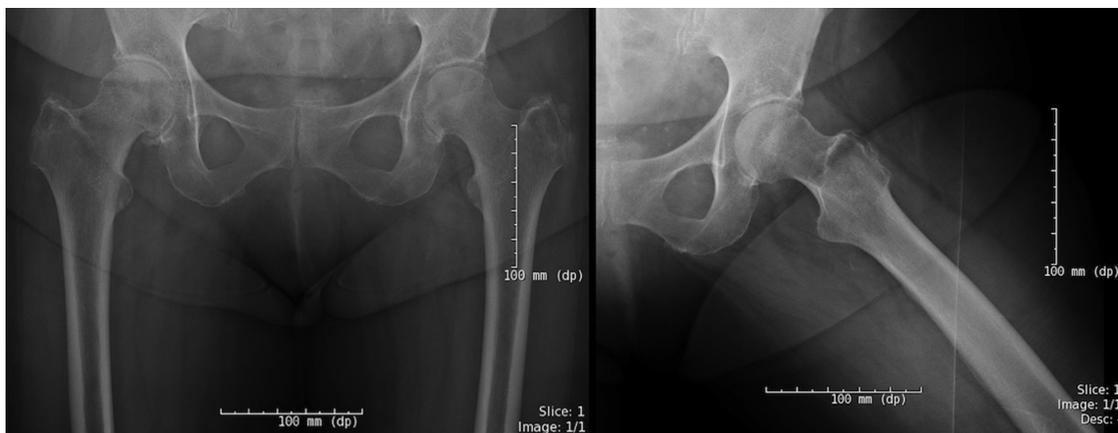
Anteroposterior pelvis and lateral x-ray studies of the left hip 1 week prior to steroid injection (6 weeks prior to emergency department visit).
